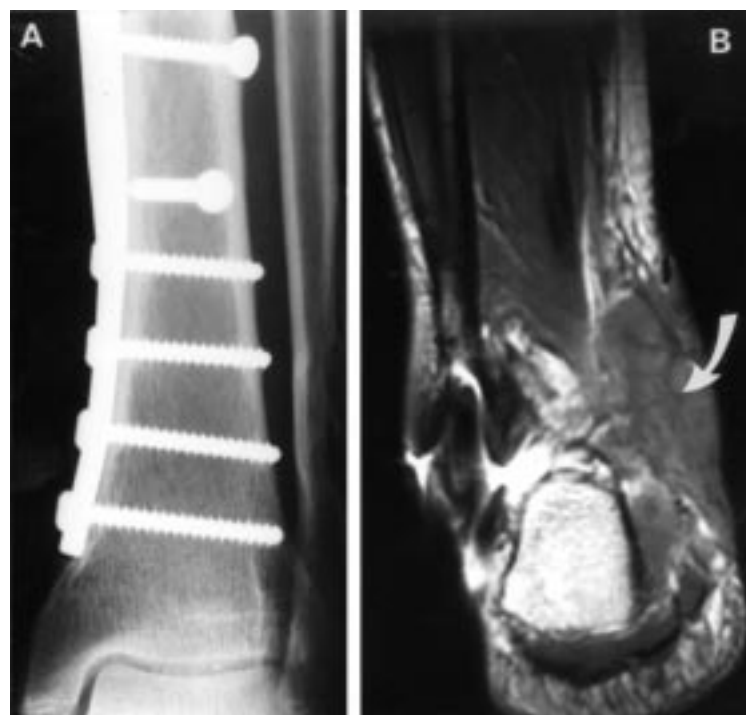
Radiograph of the tibia with internal fixation, anterior view (A); magnetic resonance imaging showed soft tissue mass (posterior view, arrow (B)).
